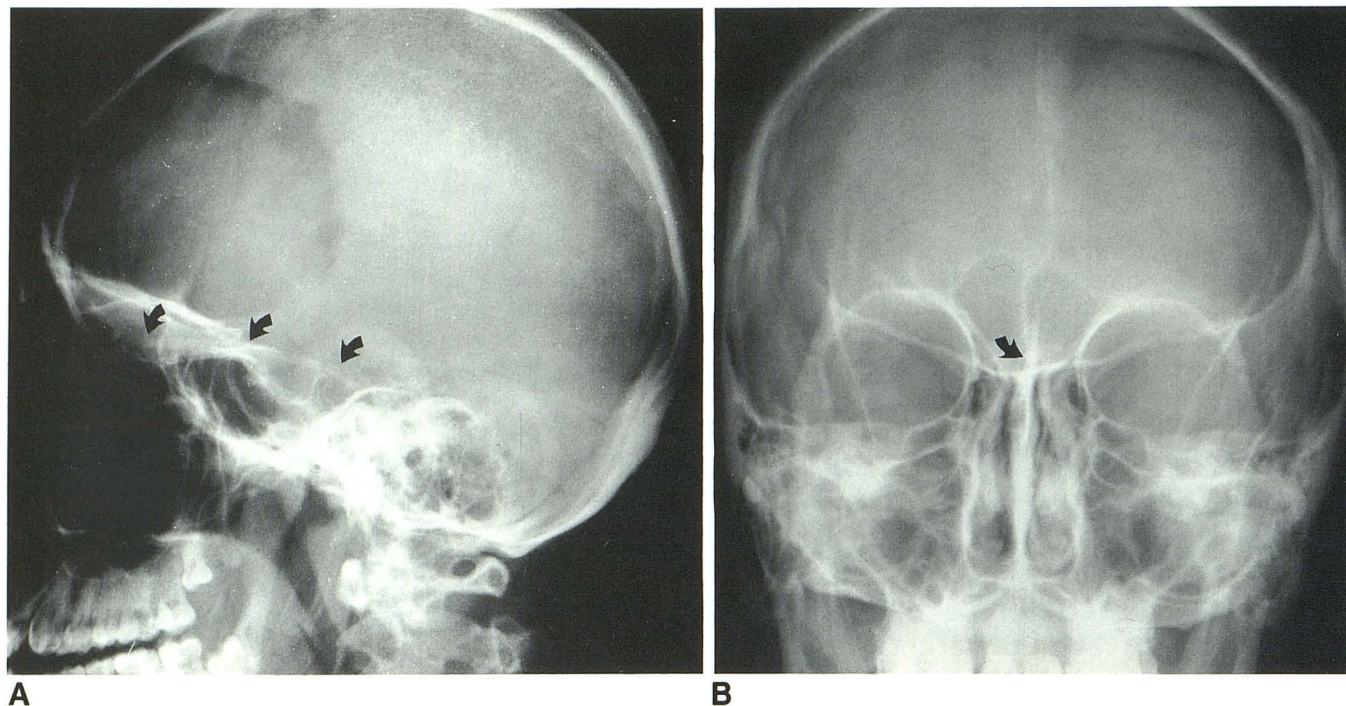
Lateral (A) and frontal (B) radiographs of the skull demonstrating the shunt tube (arrows). Note that the tube terminates blindly within the basifrontal subarachnoid space anteriorly. Note also the previous frontal craniotomy.
